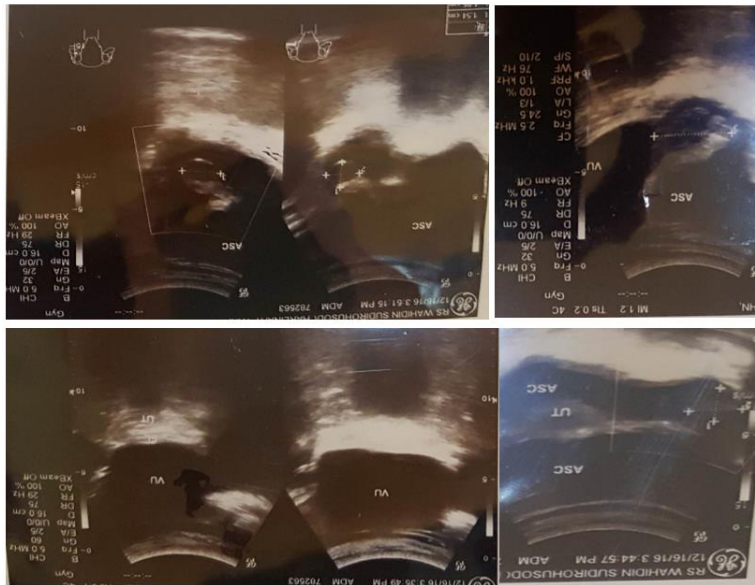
Gynecological Ultrasound
